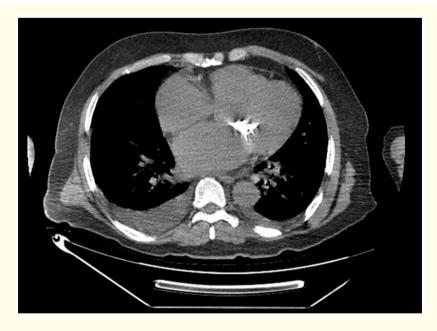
Chest CT confirming mitral leaflets calcifications.
